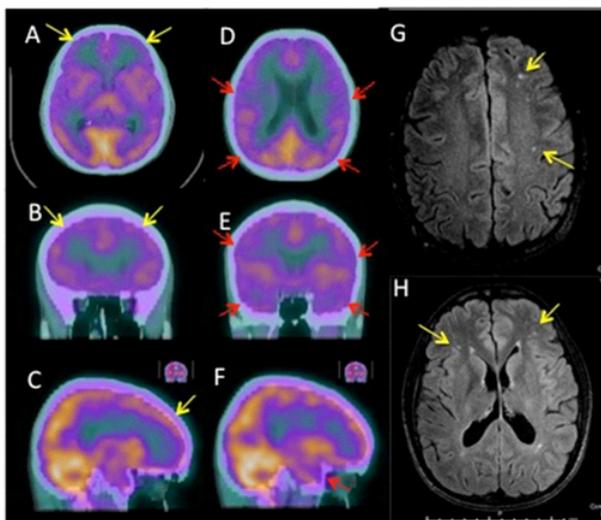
Brain perfusion SPET/CT (A-F) and related MRI imaging findings (G-H) of patient 2, axial (A, D, G, H), coronal (B, E) and sagittal (C, F) slices. Moderate with the qualitative analysis hypoperfusion is detectable in the: frontal cortex bilaterally especially in the inferior right frontal area (A-C) and the anterior and posterior temporal cortex bilaterally (D-F). Some hyperintense lesions are located in the periventricular white matter and the subcortical frontal white matter on MRI-FLAIR sequences (G-H).
